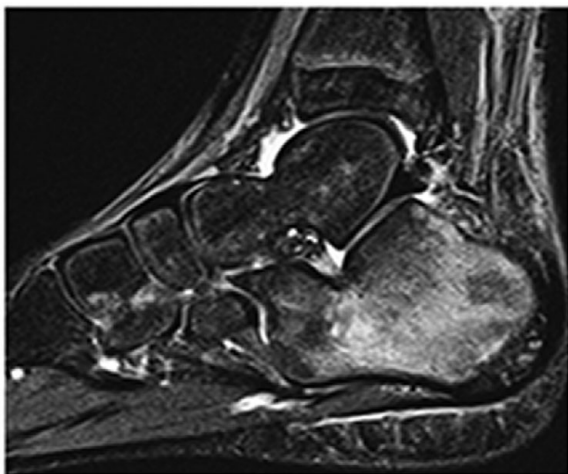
MRI T2 sagittal view ankle
